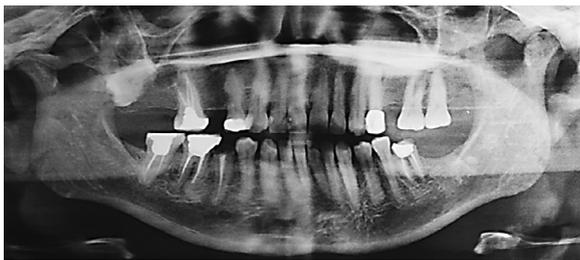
Panoramic radiograph 2 years before dental extractions showing no signs of radiolucency on the right-hand side of the mandible.
